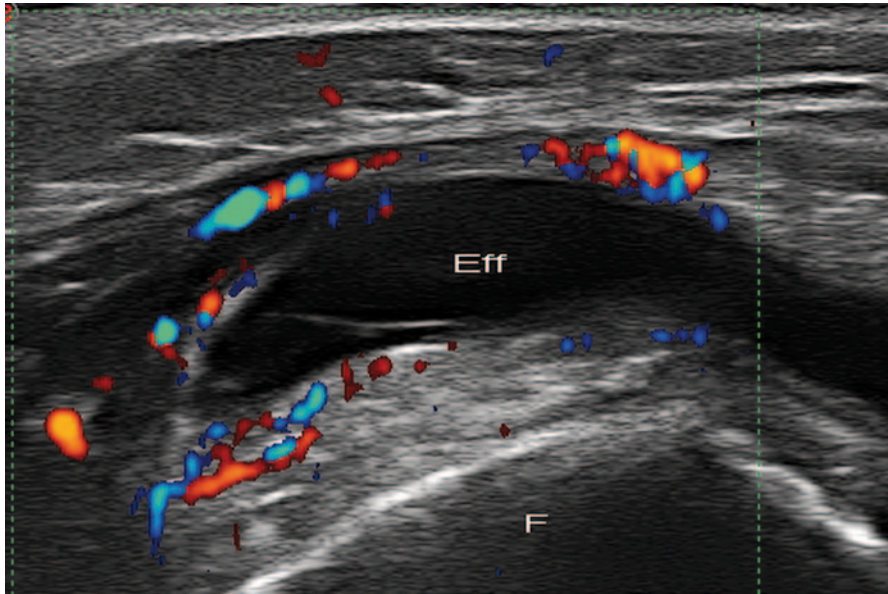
Septic arthritis. Longitudinal color Doppler US image of the knee shows suprapatellar bursitis with synovial thickness and hyperemia reflecting acute arthritis
